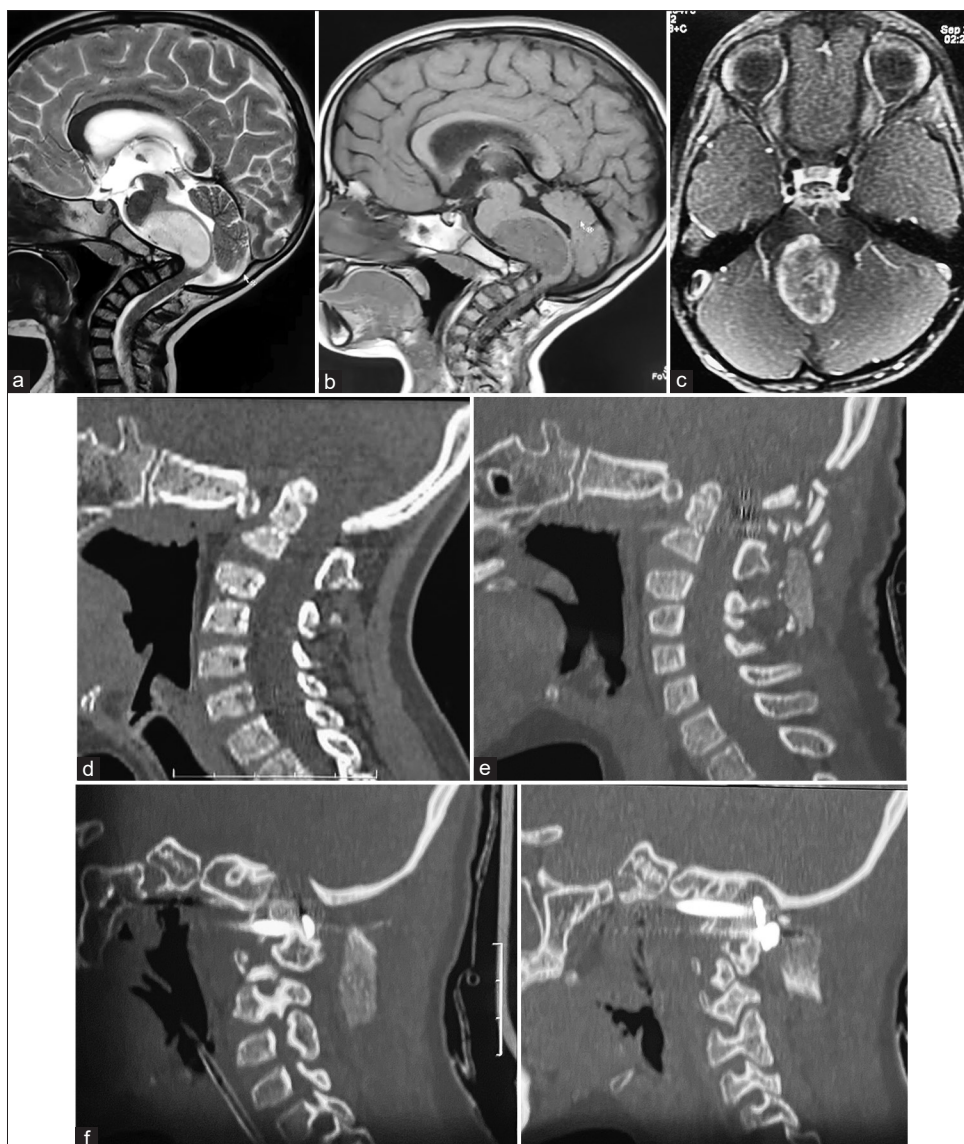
(a) T2-weighted sagittal MRI showing basilar invagination and a large brainstem hyperintense tumor. (b) T1-MRI showing the lesion to be relatively hypointense. (c) Contrast-enhanced axial image of MRI showing contrast enhancement. (d) Sagittal image of CT scan showing basilar invagination. Partial assimilation of atlas is seen. (e) Postoperative CT scan showing reduction of basilar invagination. (f) Postoperative CT scan showing the implant and bone placed for fusion. MRI – Magnetic resonance imaging, CT – Computed tomography
